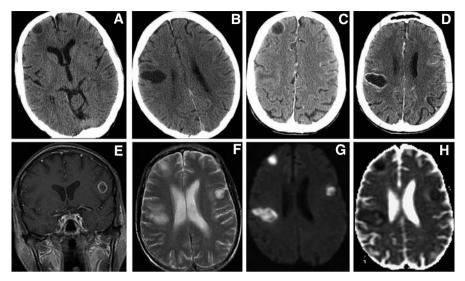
CT and MRI findings in a patient with multiple brain abscesses caused by hematogenous spread after superior digestive tract endoscopy (*Streptococcus milleri*). CT scan images (A–D) show hypodense lesions with fine ring enhancement. MRI shows them as hypointense lesions with peripheral enhancement on contrast-enhanced T1 weighted images (E). On T2 weighted images the lesions appear hyperintense with a hypointense halo (F). On diffusion weighted images the abscesses displayed a marked restricted diffusion (G) with very low ADC (H)
